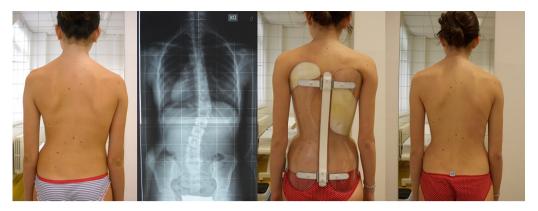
A scoliosis patient: BMI 16.44, age 11. From left to right: first evaluation, initial radiograph, her first brace, and initial esthetic results after 4 months.
